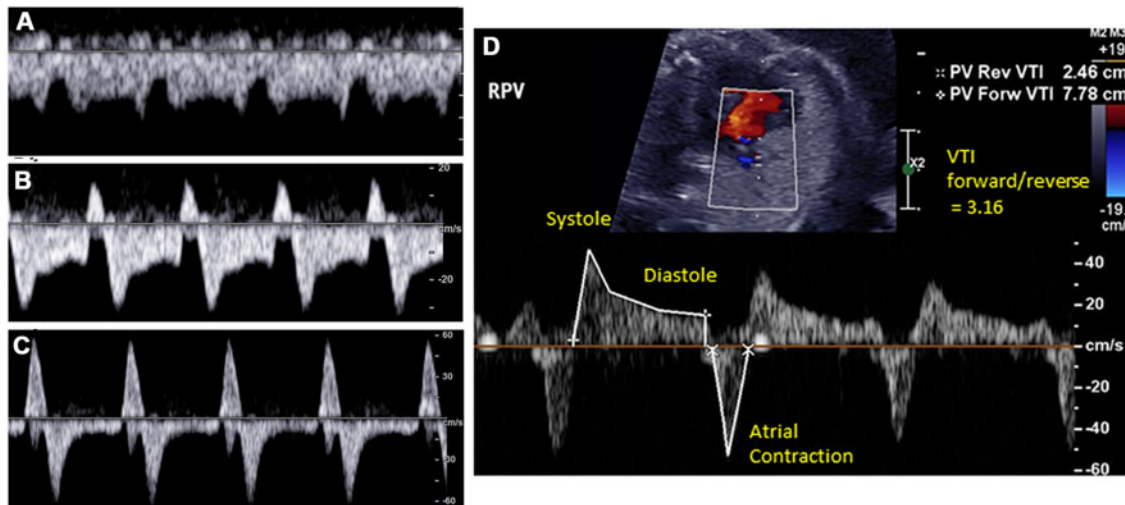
Representative spectral Doppler sample in pulmonary veins from (A) normal foetal heart demonstrating antegrade flow throughout cardiac cycle; (B) hypoplastic left heart syndrome foetal heart with small degree of flow reversal with atrial contraction; (C) hypoplastic left heart syndrome foetal heart with significant flow reversal representing severe atrial restriction; and (D) sample measurement of VTI Doppler scan. PV: pulmonary valve; RPV: right pulmonary valve; VTI: velocity time integral.
